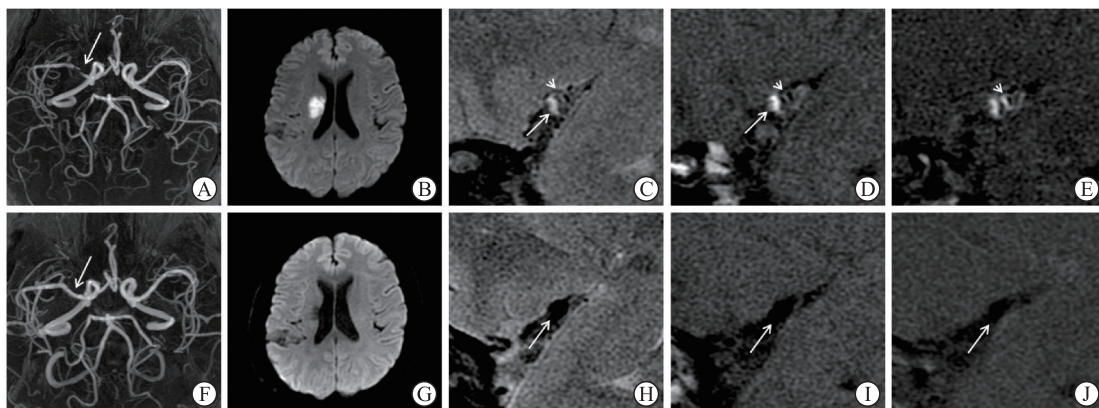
改善组 1 例大脑中动脉夹层患者药物治疗前后 HR-MRI 特征表现
